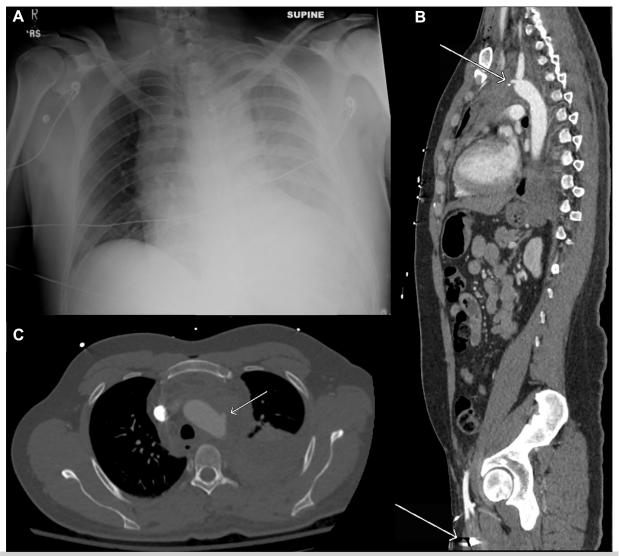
A, Chest radiograph demonstrating left hemothorax with no retained bullet. B, Sagittal reconstruction demonstrating aortic injury (*upper arrow*) and hyperdense object in left superficial femoral artery (SFA) with occlusion (*lower arrow*). C, Aortic injury proximal to left subclavian artery (*arrow*) with associated mediastinal hematoma and left hemothorax.
